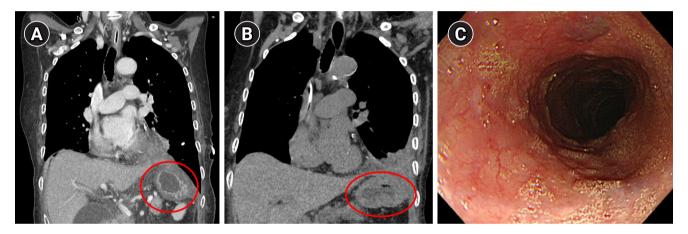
Follow-up computed tomography at postoperative day 17 (A) and 3 months (B), showing no herniation of the stomach and bowel contents (circles). (C) Esophagogastroduodenoscopy finding at postoperative 3 months, showing no clear trace of the previous perforation site.
